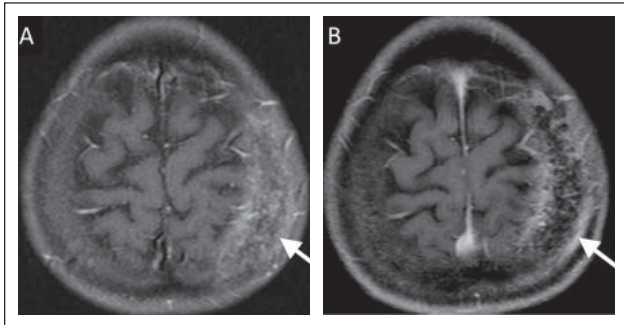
(a) T1-weighted, gadolinium-enhanced MR axial images of a 58-year-old woman with calvarial metastasis from breast cancer presenting with headache. (b) The tumour became less enhanced 3 years after 40 Gy per 20 fractions radiation therapy.
